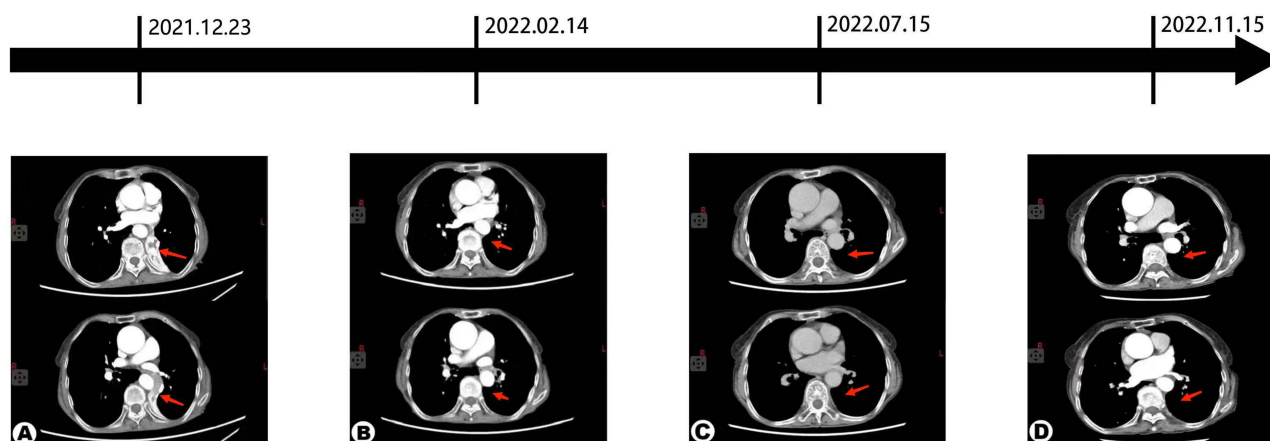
The image shows the lesion presentation on the same level of the patient's follow-up CT scan. The upper half of each image shows the most prominent area of lung atelectasis (indicated by the red arrow), while the lower half of each image depicts the largest site of the lesion (marked by the red arrow). (A) The upper part was atelectatic, and the lower part was a tumorous. (B) Comparison of patients treated with pembrolizumab combined with anlotinib after one cycle. The scan revealed bilateral subpleural linear opacities, irregularity of the left lower lobar bronchus, multiple nodular opacities, and miliary opacities, with the largest one measuring approximately 0.7 cm in the right upper lobe, presenting spiculation and adjacent pleural traction. (C) The patients were re-examined eight months after the diagnosis of lung cancer. (D) The patients were re-examined twelve months after the diagnosis of lung cancer.
